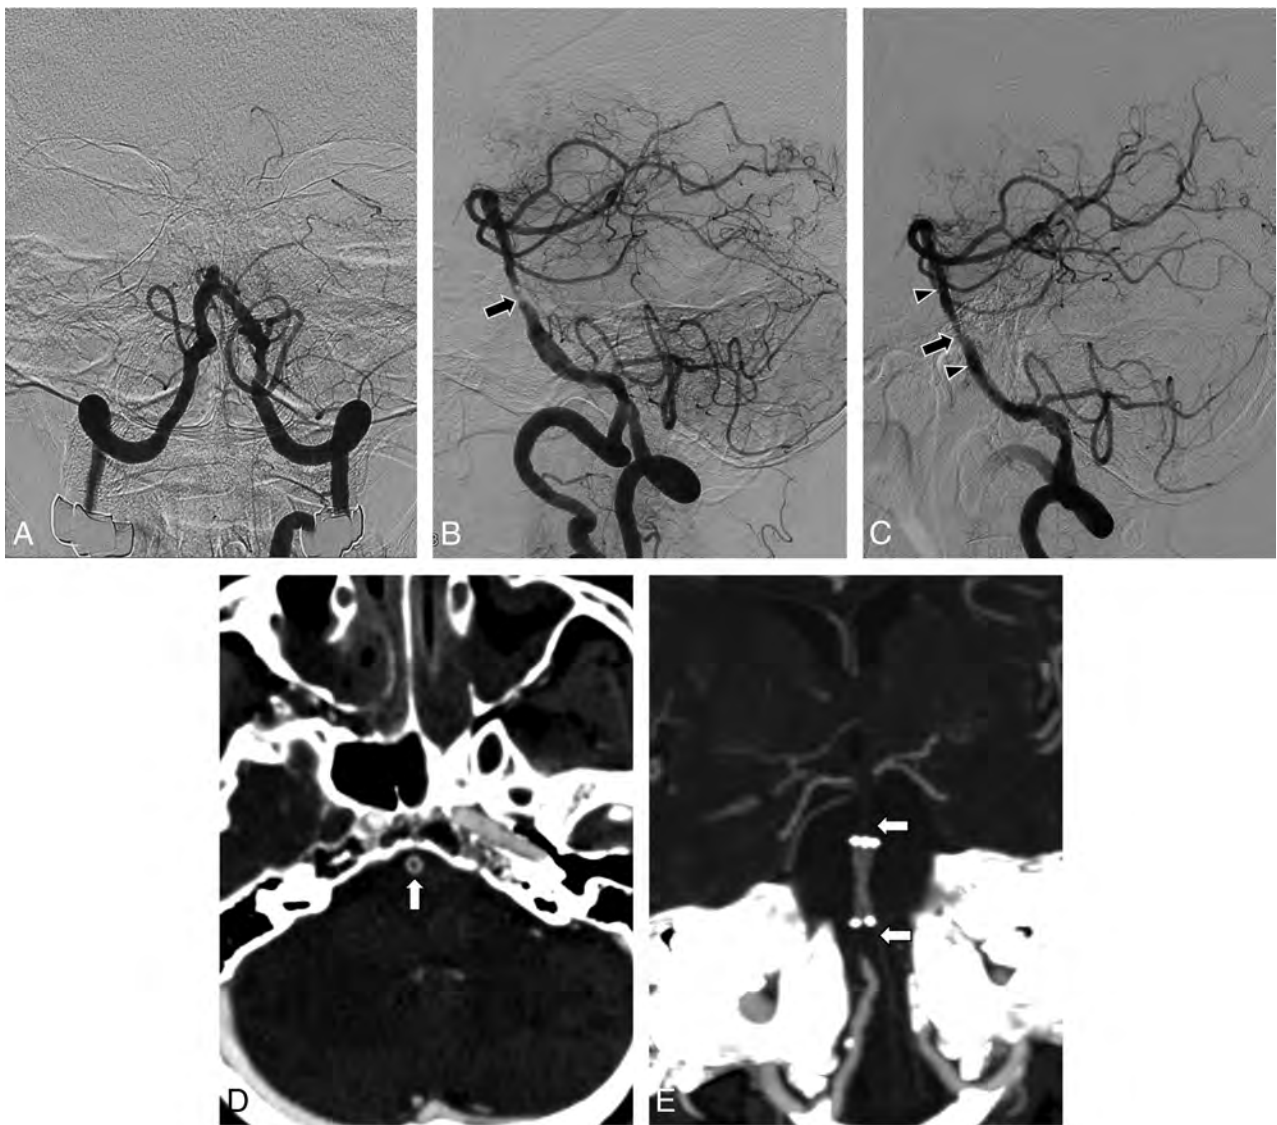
Brain images obtained in a patient with acute stroke. *A*, Anteroposterior view of a vertebral angiogram shows arterial occlusion at the proximal portion of the basilar artery. *B*, Lateral projection of the vertebral angiogram obtained after stent-retriever embolectomy reveals severe underlying stenosis (arrow) at the site of arterial occlusion. There were no retrieved thrombi with the Solitaire stent. *C*, Lateral projection of vertebral angiography performed after intracranial stent placement shows suboptimal angioplasty, with residual stenosis of 60% (arrow). Arrowheads indicate the proximal and distal ends of the stent. *D*, Axial source image of CTA shows hypoattenuation (arrow) within the stented segment of the basilar artery. *E*, Maximum-intensity-projection image of the follow-up CTA 2 days after the procedure shows a discontinuation of the contrast column both proximal and distal to the stent (arrows).
